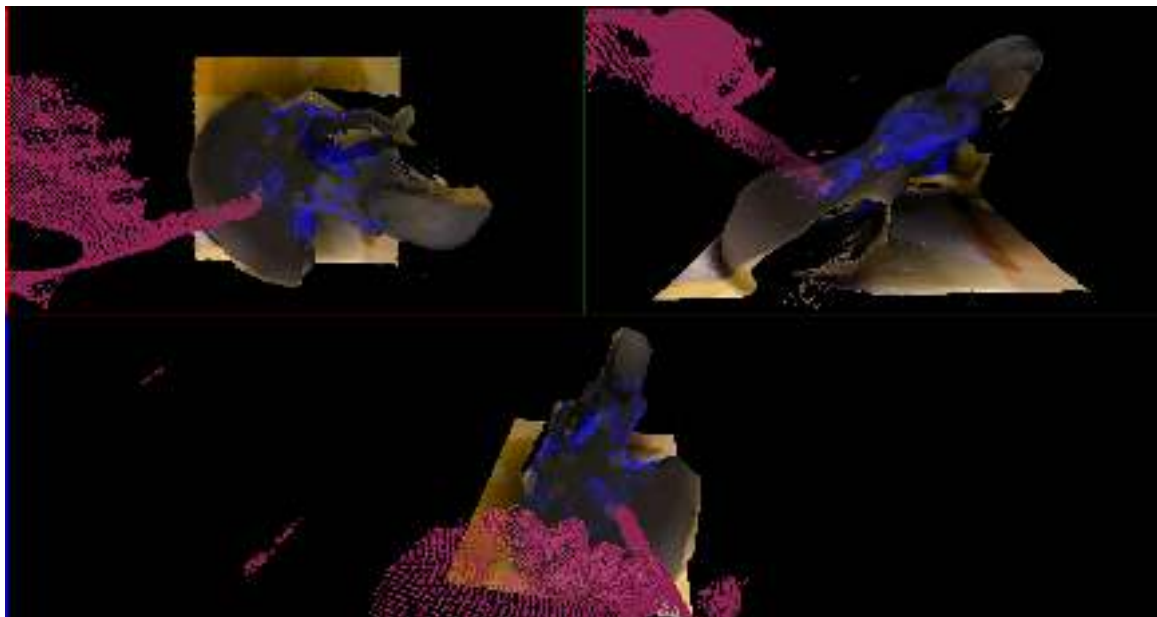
Example of Multiple Views of Mixed Reality Visualization - overlaying of CBCT volume and reconstructed surface with fade out windows and live flying point clouds for user interaction.
